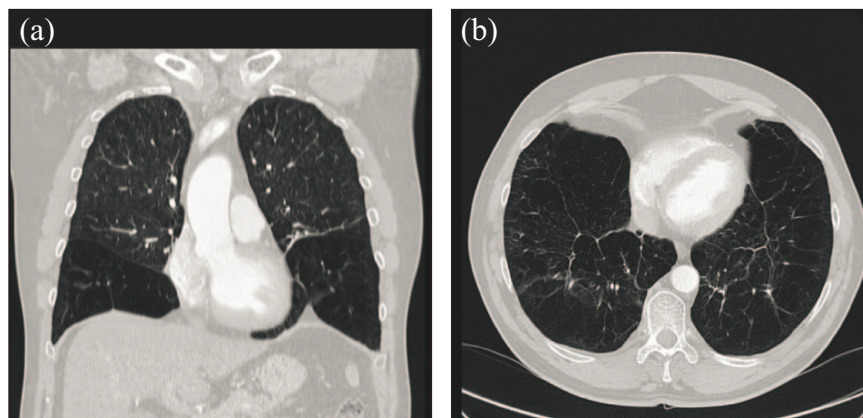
Typical presentation of emphysema in AATD. Chest CT scan (a) coronal cut; (b) axial view of an AATD patient with basal-predominantly emphysema. AATD, alpha-1 antitrypsin deficiency; CT, computed tomography. Reproduced with permission from Newell *et al.*³⁸
